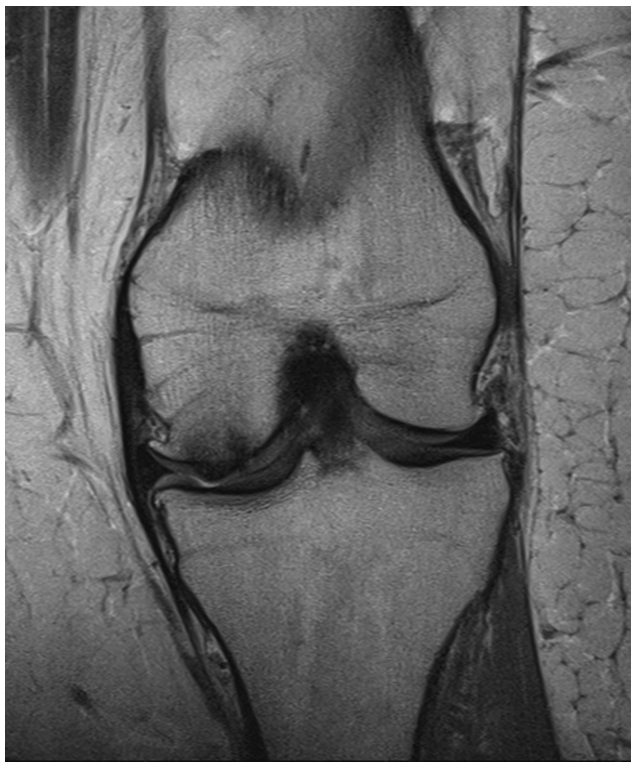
Preoperative coronal T₁-weighted magnetic resonance imaging shows prominence of osteochondral graft in distal left knee medial femoral condyle. Note adjacent tibial plateau chondral surface.
